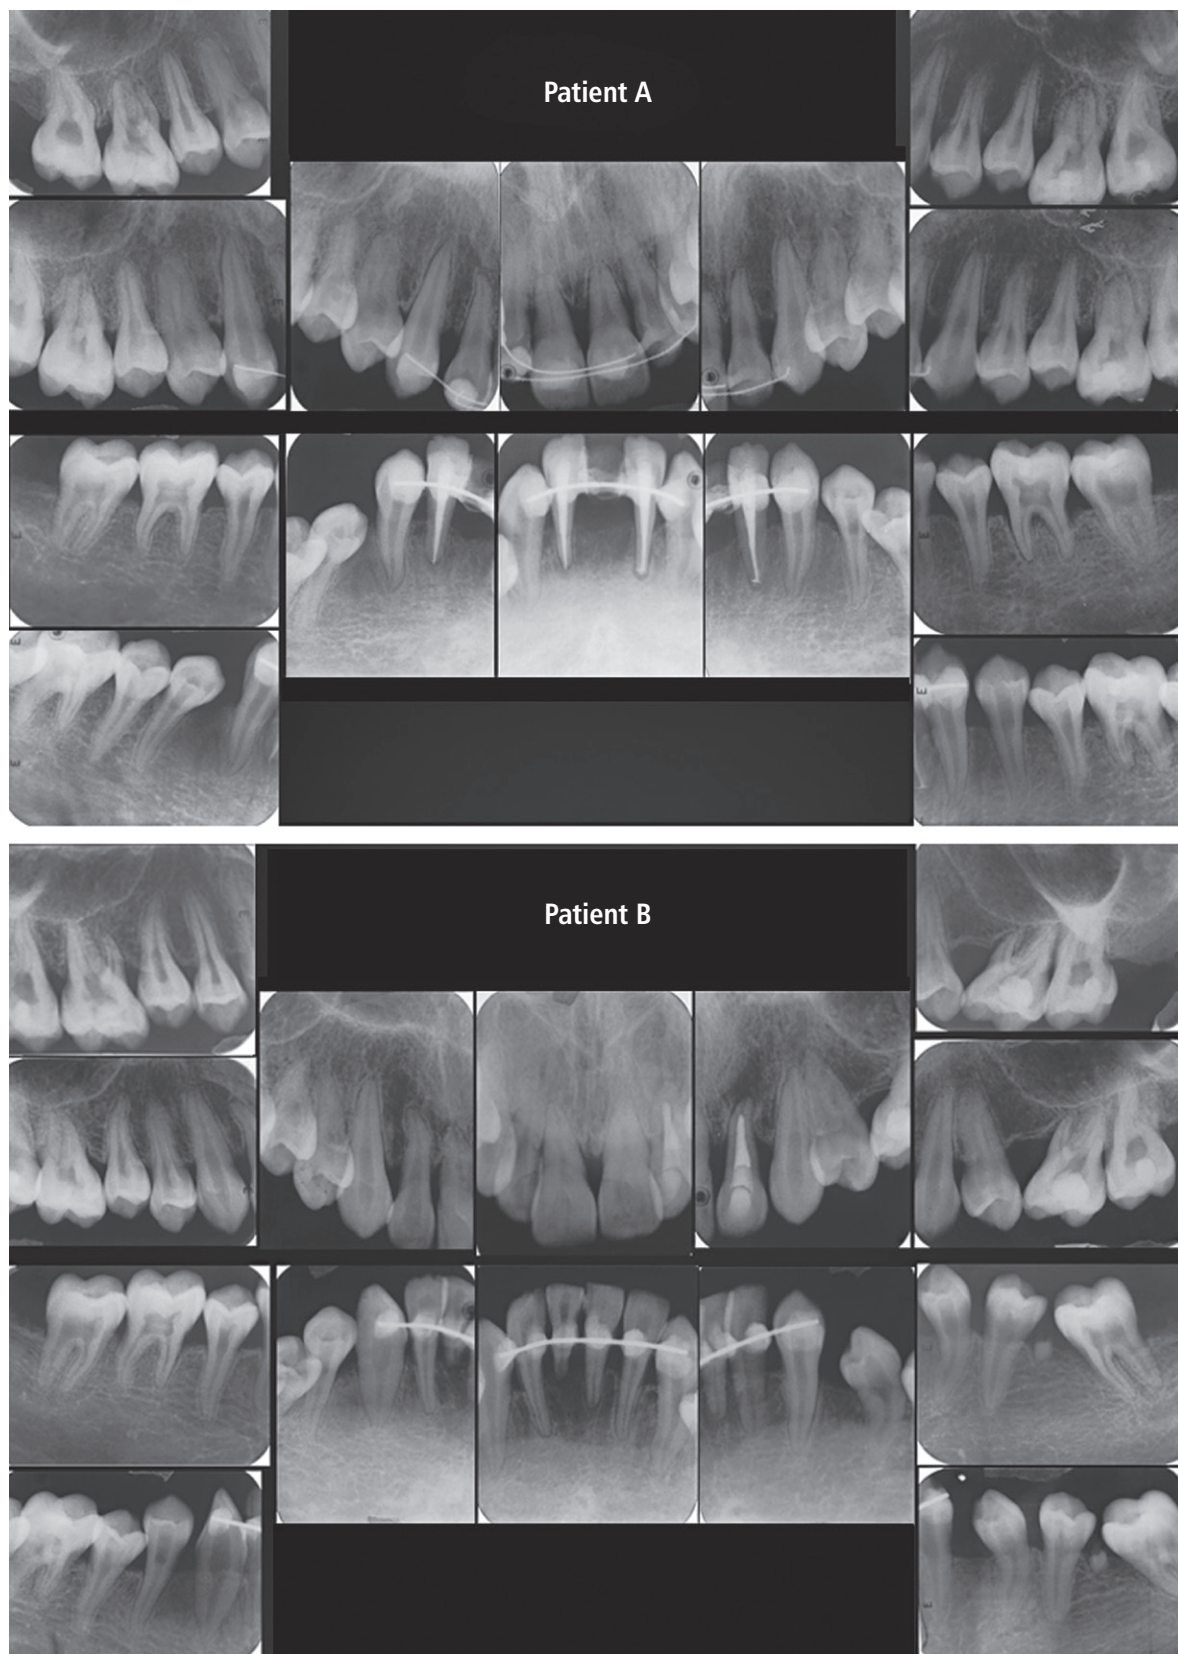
Full-mouth periapical radiographs of patients A and B taken at 20 years of age showing reduced alveolar bone height, short root length, and abnormally wide pulp chambers and root canal systems in several teeth. Note that teeth splinting was necessary for both patients and that endodontic treatment was performed because of pulp necrosis. For patient B, a root tip was evident in the molar region of the lower left side, which was later extracted. Although there was an evident and significant amount of bone loss observed for both individuals with furcation involvement in some teeth, probing depth was always ≤ 3 mm with minimal bleeding.
